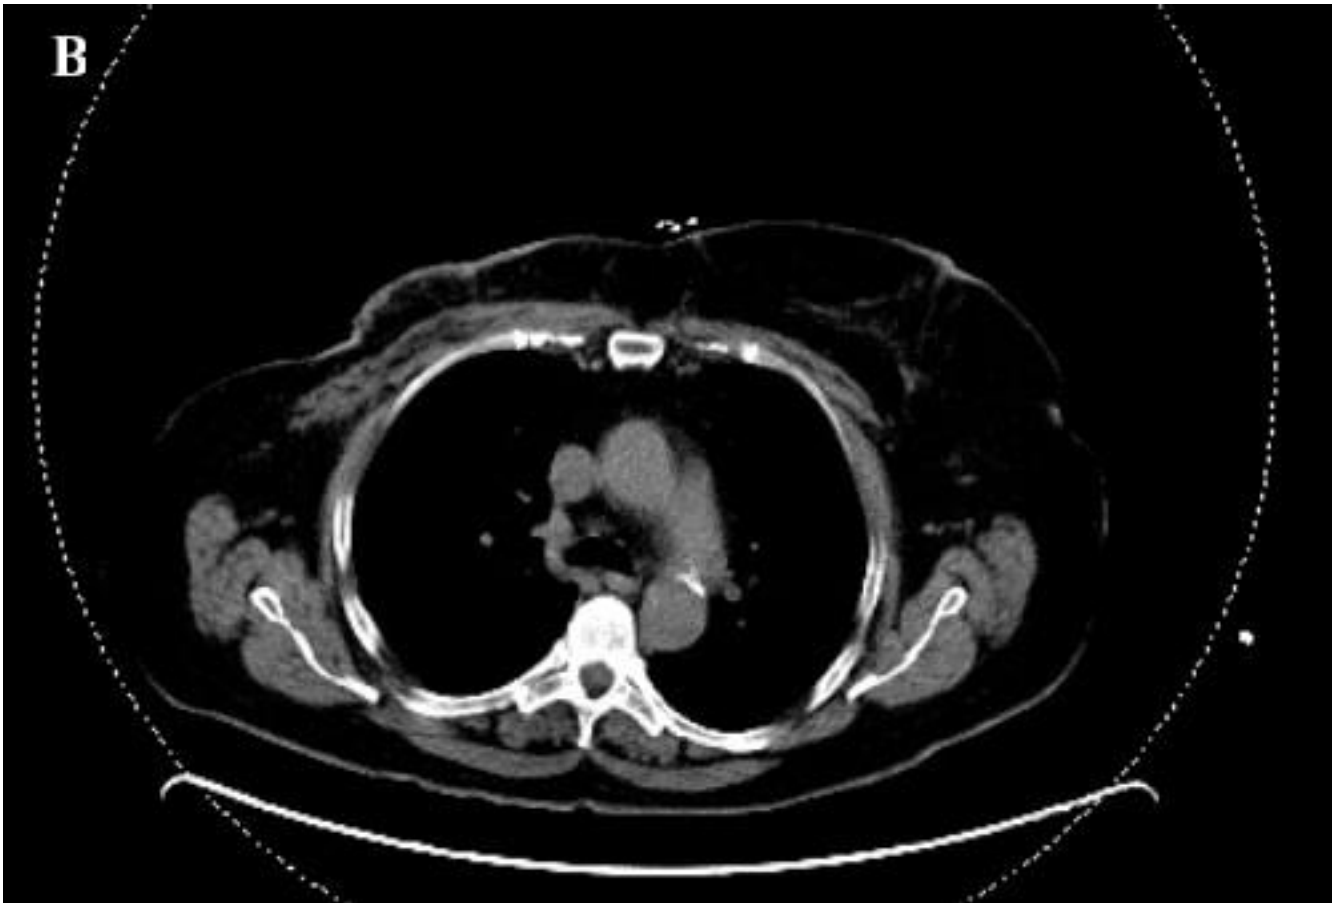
Computed tomography after en bloc capsulectomy in axial section.
